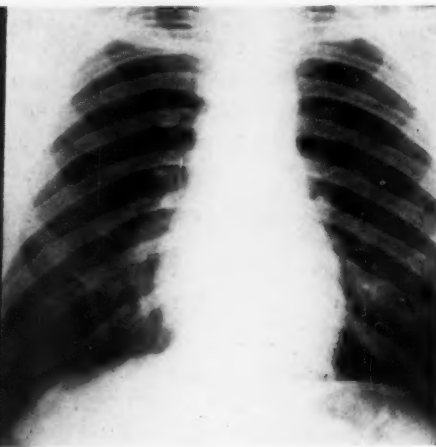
Six-foot roentgenogram, October 7, 1939, three months postoperative showing further narrowing of the superior mediastinum and a normal cardiac shadow.
